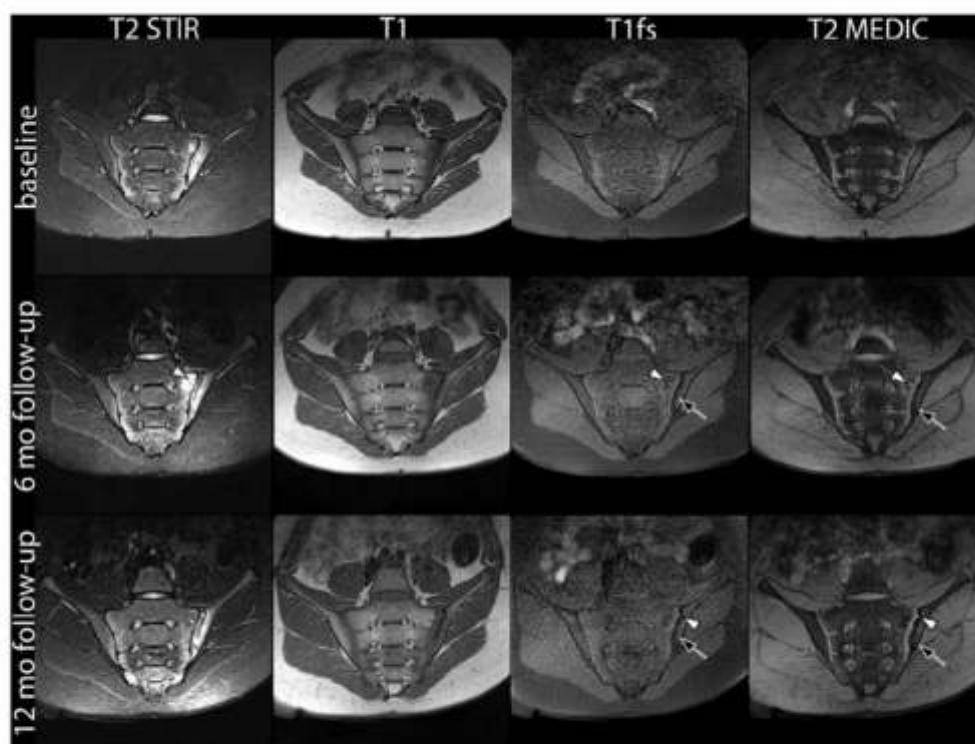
An 11-year-old boy with JIA enthesitis-related arthritis subtype. The initial examination was obtained at the age of 11 years; first follow-up MR imaging was obtained 6 months later, and second follow-up, 12 months after baseline. Left-sided sacroiliitis: semicoronal T2 short-tau inversion recovery images show bone marrow edema in the left ilium, joint space inflammation, capsulitis, and active erosion in the left sacral bone (evident in the first follow-up examination; arrow). T1, T1 fat-suppressed, and T2 MEDIC consecutive examinations show increasing number of erosions (white arrows) and bone marrow fatty metaplasia (black arrows).
